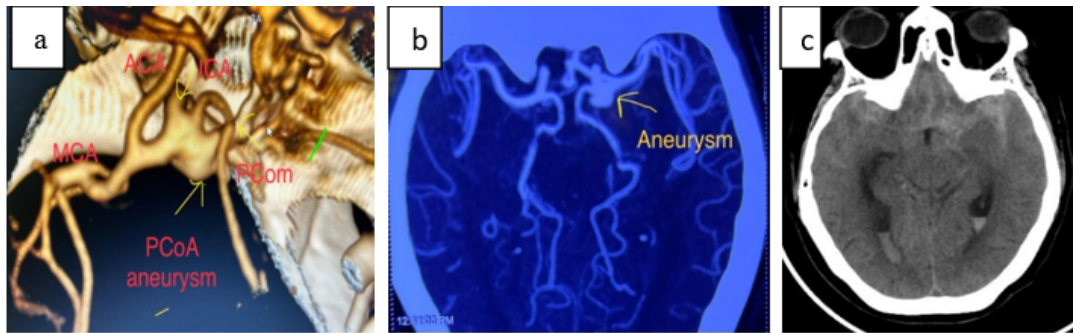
a: CT brain angiography 3D showing large wide neck PCoA aneurysm projecting inferiorly; b: CT brain angiography showing PCoA aneurysm with wide neck; c: CT brain plain showing diffuse SAH with bilateral IVH
